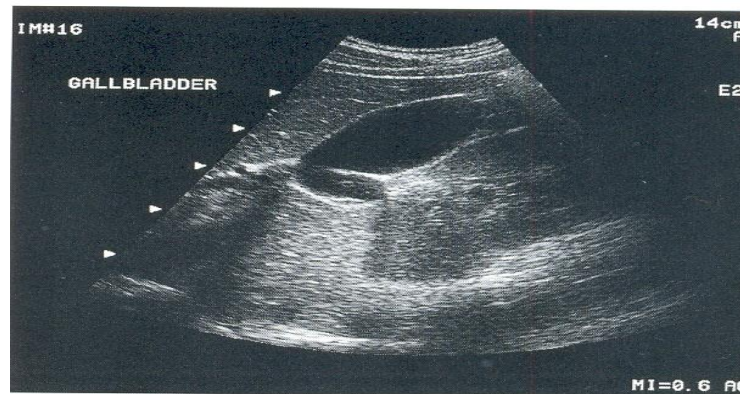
4sonographic appearance of the gallbladder
